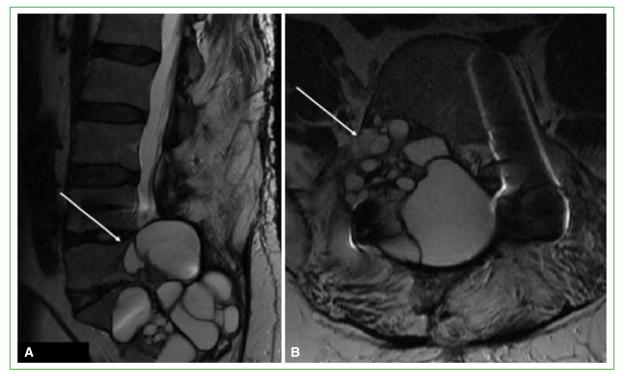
Lumbar spine MRI. A and B. Sagittal and transverse sections. Multiple cystic lesions related to L4-L5 and S1, showing intraspinal involvement (May 2014).
